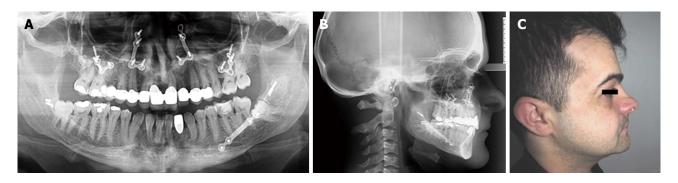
Radiographic and clinical evaluation after 5 years follow-up period. A: Panaromic radiography 5 years after orthognathic surgery reveals preserved and unchanged dental alignment; B: Dental class I occlusal relationship is clearly seen on sephalometric radiography; C: Profile appearance of the patient seems satisfying.
